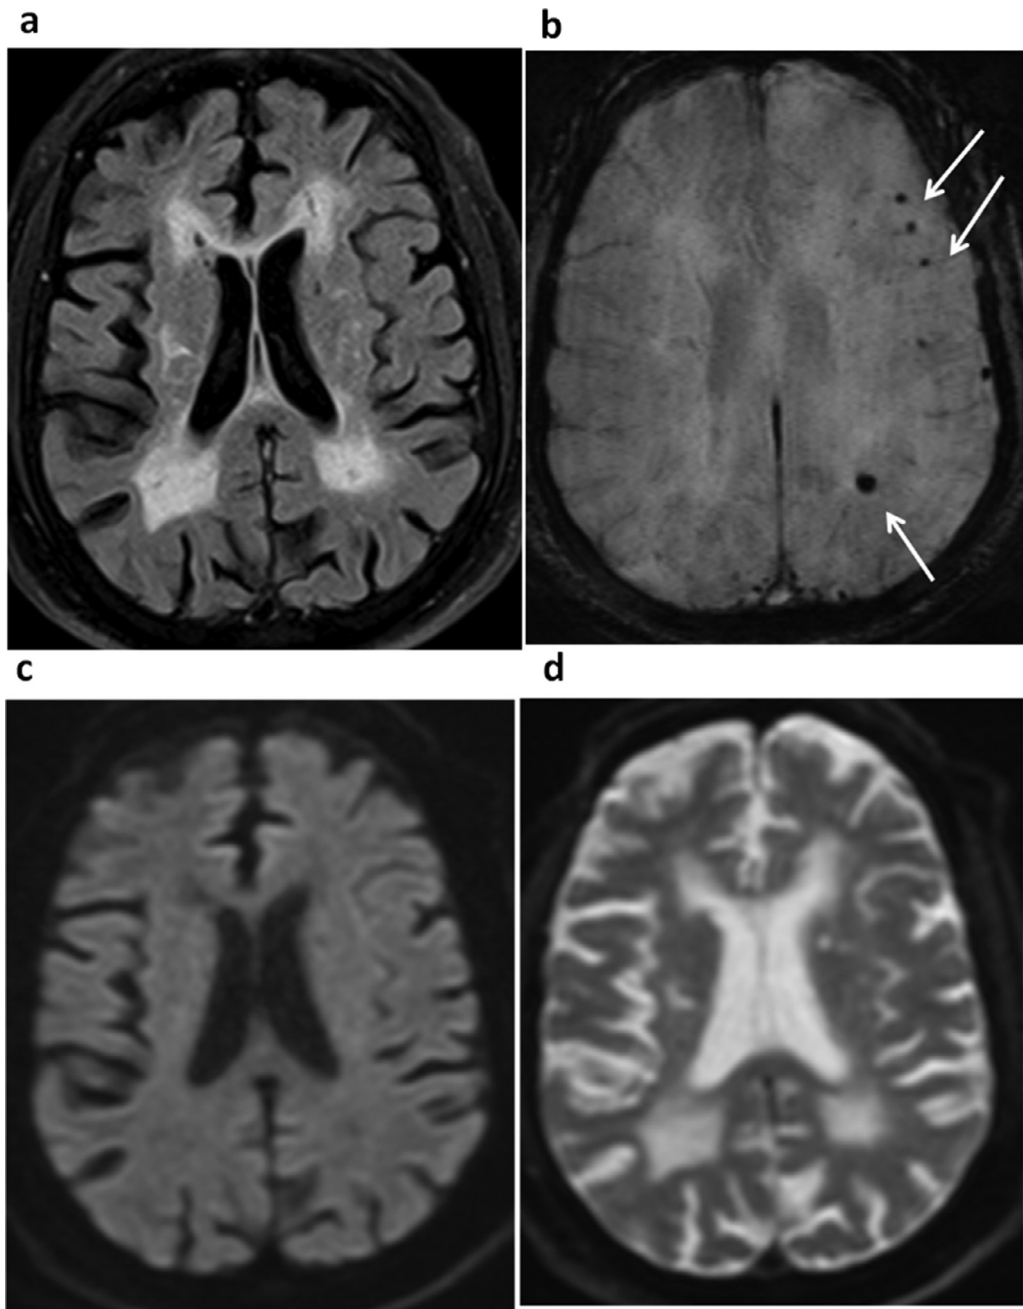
Diffuse leukoencephalopathy in a 64 years old male admitted in ICU. (A) Axial FLAIR MR reveals diffuse confluent white matter hyperintensity in bilateral corona radiata and centrum semiovale (not shown). (B) Axial GRE (Gradient echo) reveals multiple microhemorrhages in left gray-white matter junction (arrows). (C) Diffusion weighted imaging (DWI) B = 1000 and (D) Apparent diffusion coefficient (ADC) map reveals no diffusion restriction.
